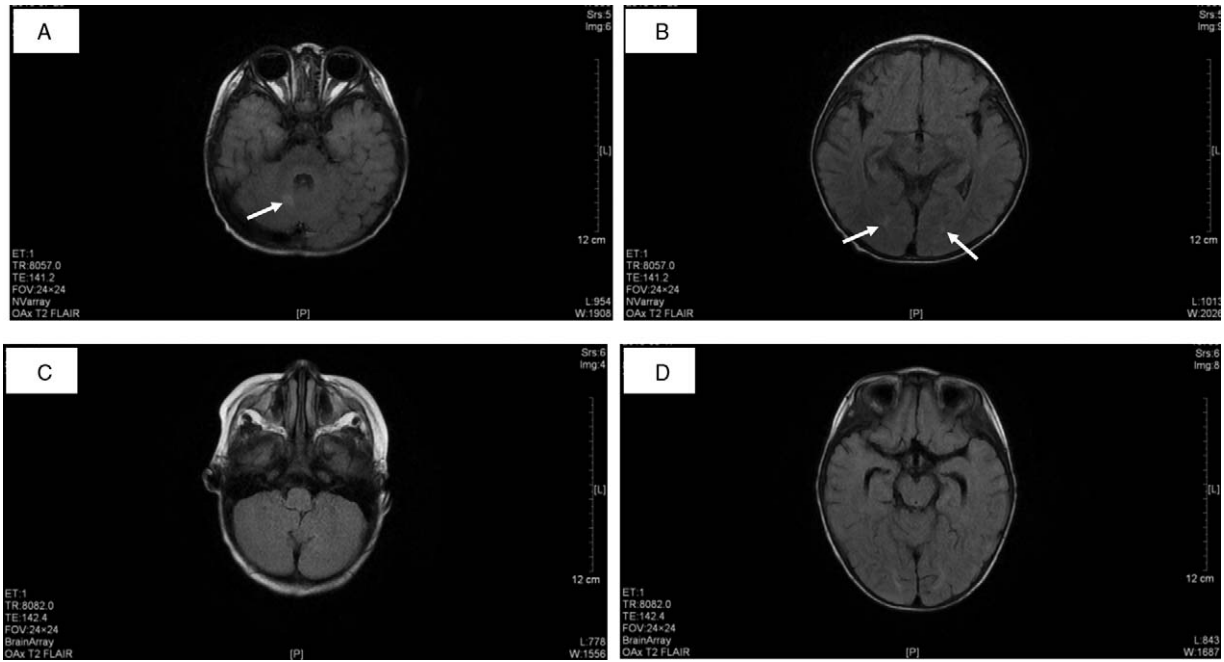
Magnetic resonance imaging on the heads of the patients after admission. T2 FLAIR signal in the right cerebellar hemisphere (A) and signal in the bilateral occipital lobe (B) of patient 1. T2 FLAIR signal in the right cerebellar hemisphere (C) and in the bilateral occipital lobe (D) of patient 2.
